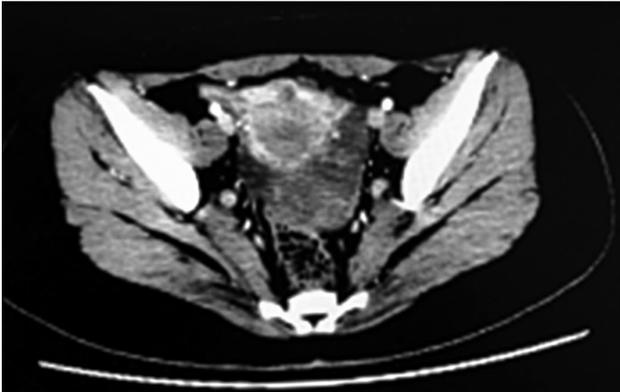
CT views of the third surgery.
